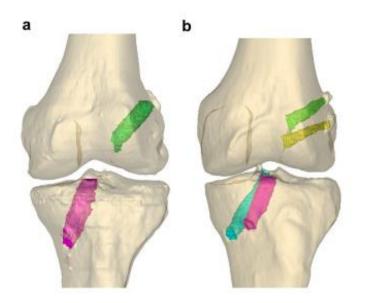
a Single-bundle ACL reconstruction knee in a 3D CT model with one tunnel on each side of the joint. b Double-bundle ACL reconstruction knee in a 3D CT model with 2 tunnels in the femur AM (green) and femur PL (yellow) and two tunnels in the tibia AM (fuchsia) and tibia PL (cyan)<sup>7</sup>
